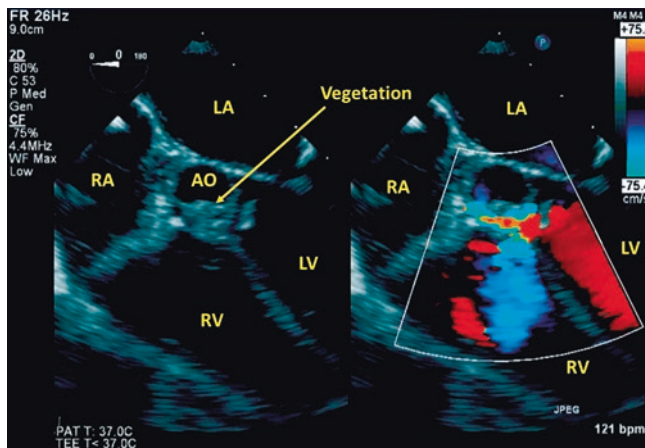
Case #1. Vegetation is seen on the aortic valve from endocarditis in the midesophageal five-chamber view. There is a ventricular septal defect that occurred as a complication of the endocarditis, and color Doppler shows flow across the defect. AO aorta, LA left atrium, LV left ventricle, RA right atrium, RV right ventricle
